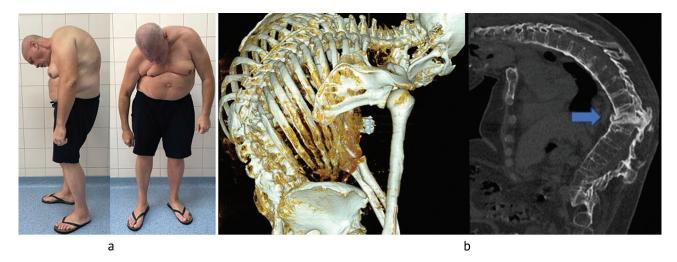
Preoperative photograph and CT scan of the thoracic and lumbar spine showing (a) patient's posture, pronounced kyphoscoliosis; (b) CT scan 3D VRT and MPR, sagittal view, signs of Andersson lesion, wedge-shaped deformity of Th₁₂ and L₁, ventral spontaneous fusion and ossification of the anterior longitudinal ligament
